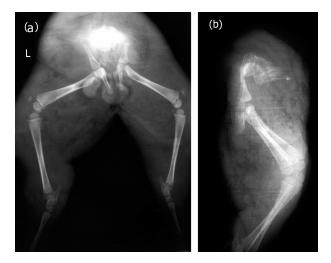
Ventro-dorsal radiographic projection: the presence of a disproportionate area of soft tissue embedding the two hind limbs, the pelvis and a malformed portion of the vertebral column (a). Lateral radiographic projection: the vertebral column appeared malformed, turned at an angle of 90° and cranially shifted (b)
